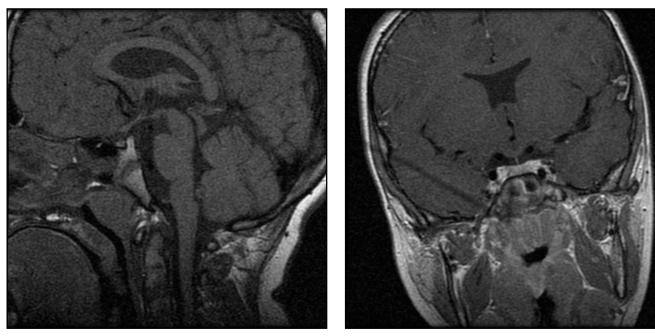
Sagittal T1-weighted image showing hypoplastic anterior pituitary and absence of septum pellucidum.
